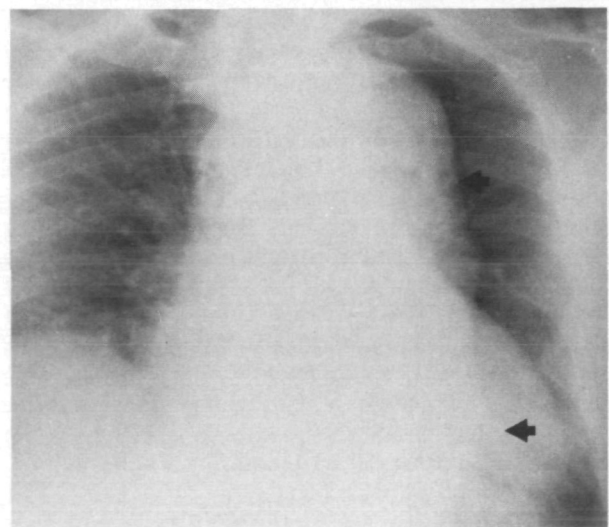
Patient 3. A frontal chest radiograph shows enlargement of the mediastinum as a result of widening and tortuosity of the descending thoracic aorta (arrows). The left ventricle is enlarged and the right hemidiaphragm is elevated.
